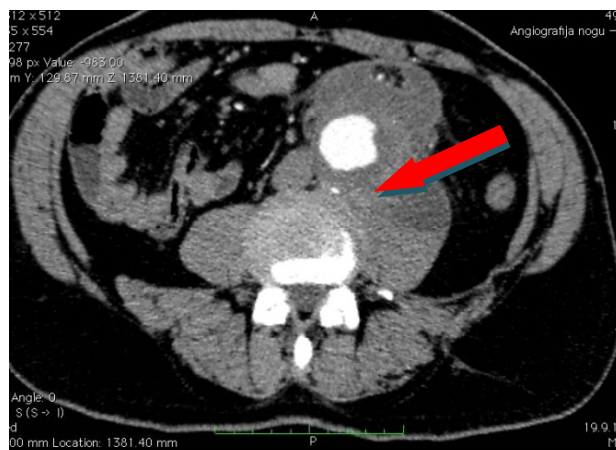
Infrarenal suprailiac aneurysm of the abdominal aorta with the maximal anteroposterior diameter of 72 mm and the large retroperitoneal haematoma extending into the left iliopsoas muscle and left paracolic gutter on multislice computed tomography scan angiography. (Retroperitoneal hematoma marked with a red arrow)
